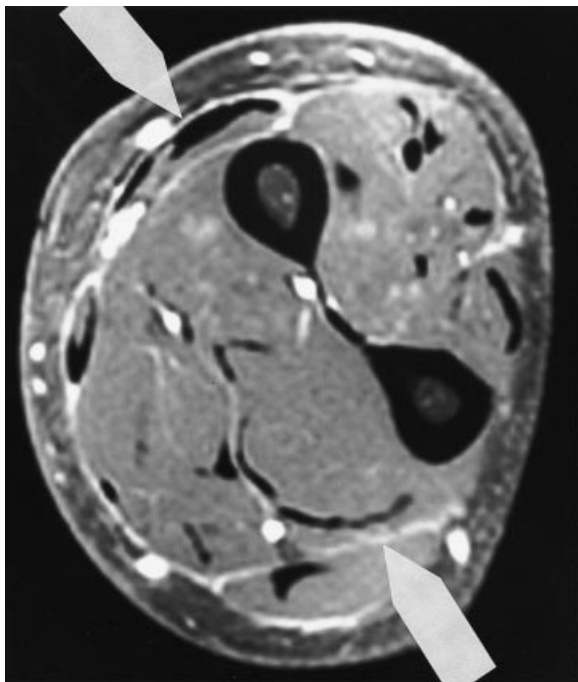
MRI of forearm with gadolinium injection: a T1 image showing contrast enhancement of perimysial and intermuscular fascia (arrows).
